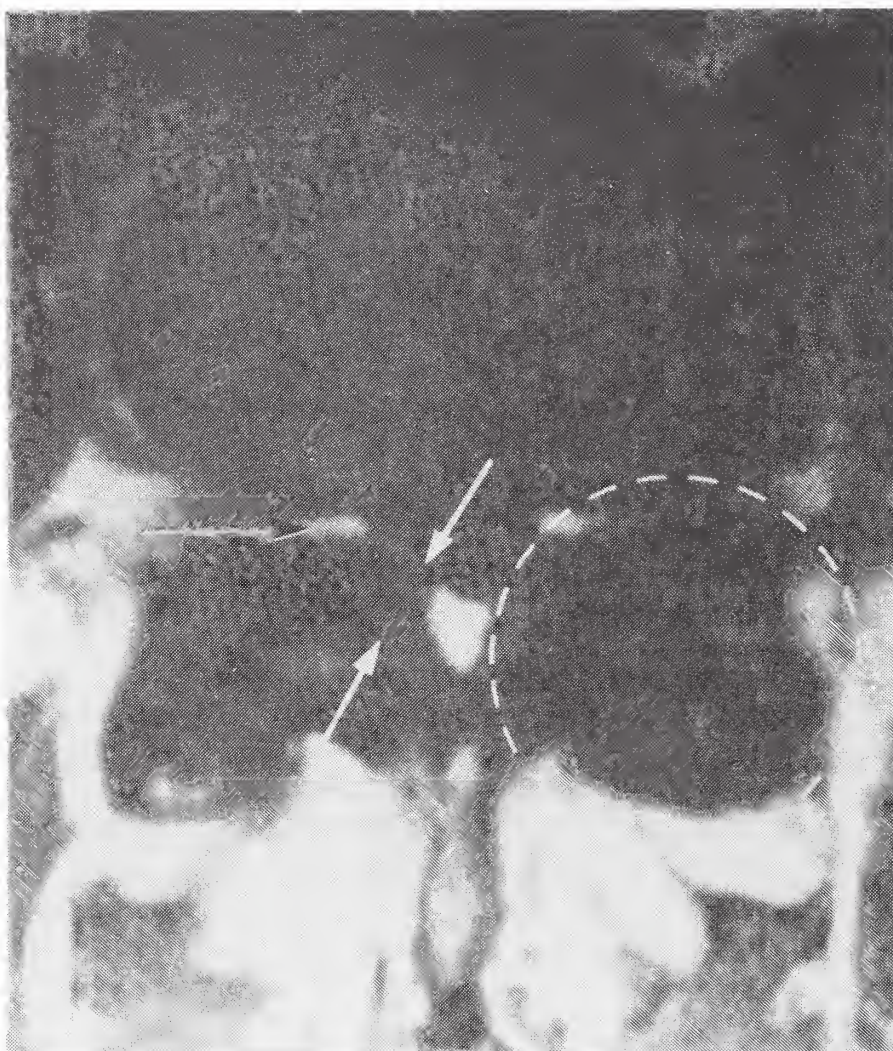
Spinal and foraminal stenosis, T2-weighted MRI, axial view. The white circle on the right indicates the severely enlarged facet joint complex which causes neural foraminal and lateral recess stenosis (black arrow, left). Osteophytes and severely thickened ligamentum flavum (two white arrows, left) contribute to narrowing of the spinal canal in the sagittal plane.
